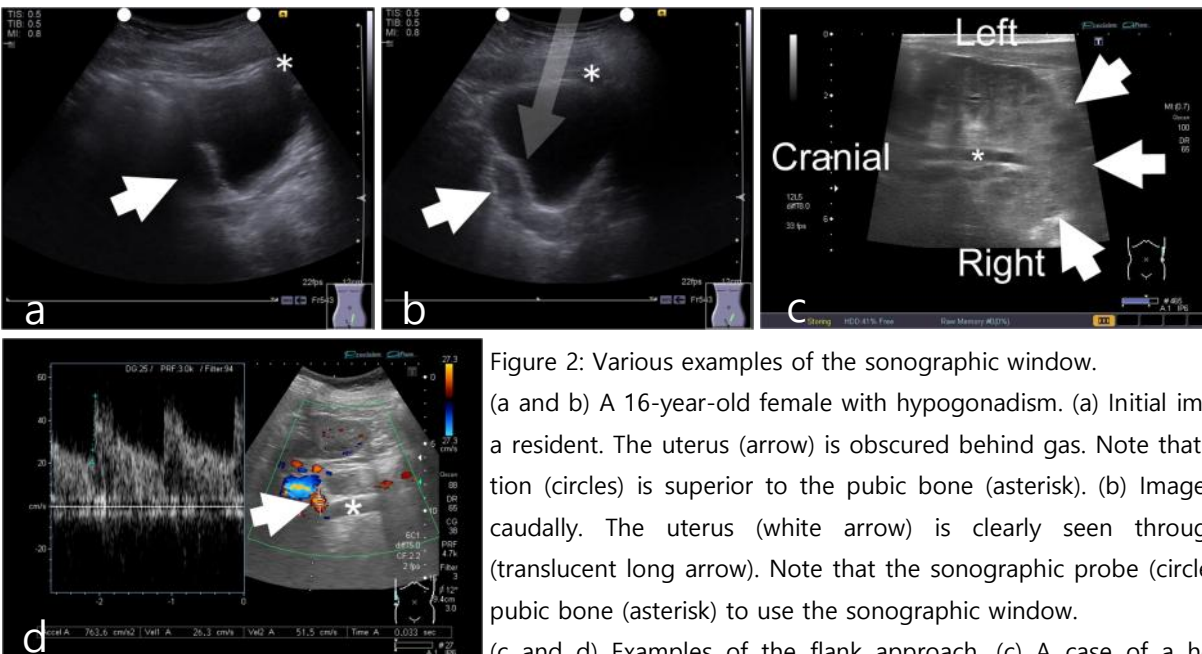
Various examples of the sonographic window.
